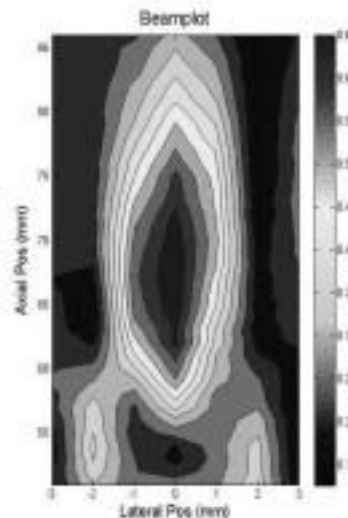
Contour map of the focal zone in ultrasonic field along the axial direction
